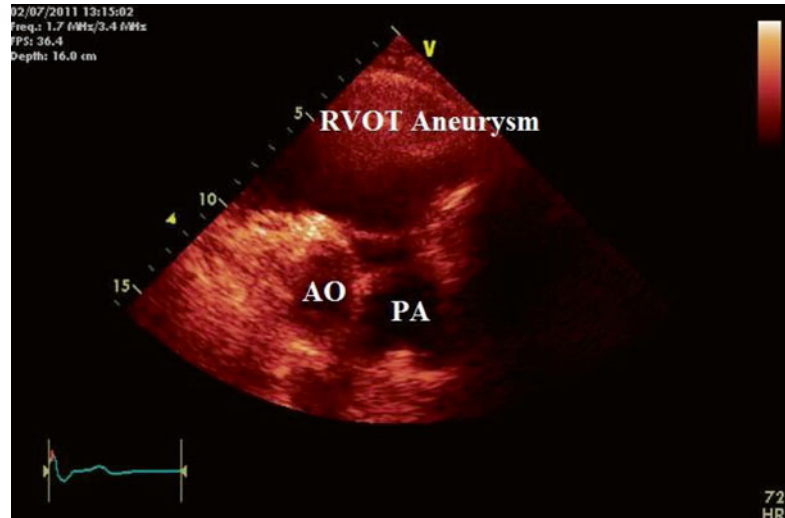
(a, b) A typical patient with history of repaired TOF and severe pulmonary regurgitation by color flow imaging and Doppler study
